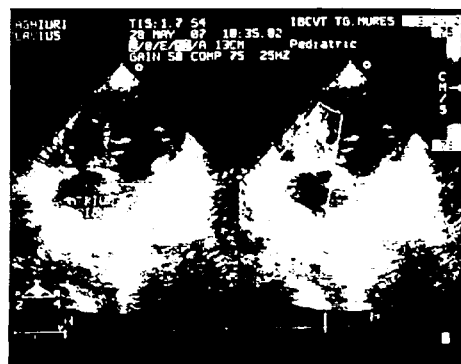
Apical four chamber - Doppler and color flow examination
